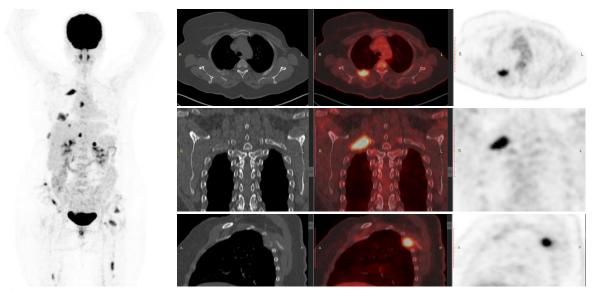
A 43-yrs-old female with left sided infiltrative ductal carcinoma of the breast, underwent PET/CT scan (a: axial, b: coronal, c: sagittal) demonstrates metastatic lytic osseous lesion in right 3rd rib posteriorly, its metabolic parameters (SUV max 8.5, SUV mean 5.3, MTV 5.7, TLG 30.2, peak 6.7).
